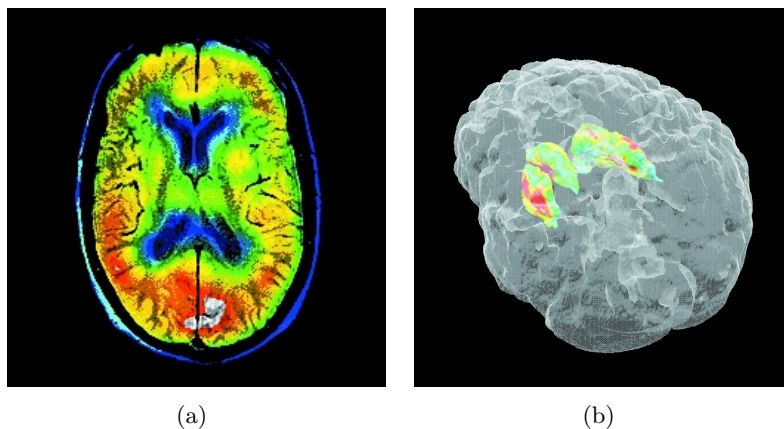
Example of co-registered 2D SPECT-MRI images (a) and example of co-registered 3D image of the brain (MR) and basal ganglia (PET- $^{18}\text{F}$ ) (b) [85].
